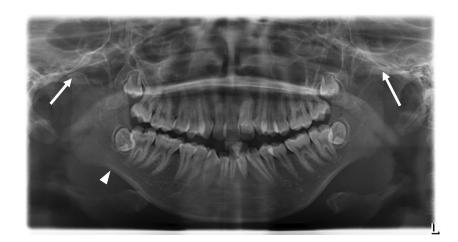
Panoramic radiograph: Mandibular antegonial depression (arrowhead) and flattened mandibular condyles (white arrow).
